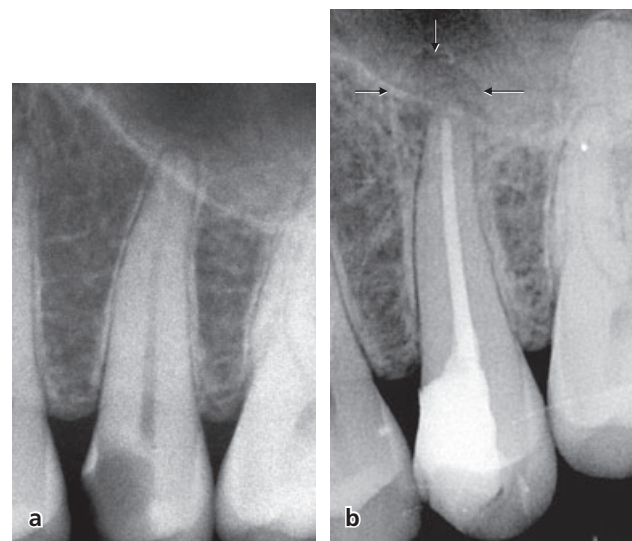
(a) Radiograph of an upper second premolar with caries extending to the vicinity of the pulp. There is loss of lamina dura at the root tip. (b) The 3-year recall radiograph after pulpectomy of the vital pulp and root filling shows a periapical radiolucency suggesting existence of a persistent root canal infection in this case.
